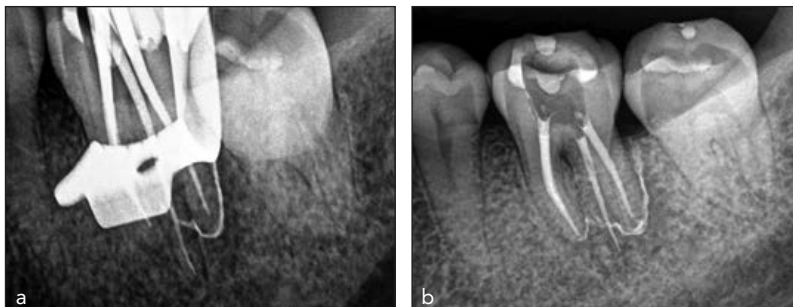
CH extruded into a periodontal-endodontic lesion at time of pulpectomy associated with clinical closure of prior sinus tract and periodontal pocket. Radiographs taken at time of cone fit (a) and postobturation (b).
